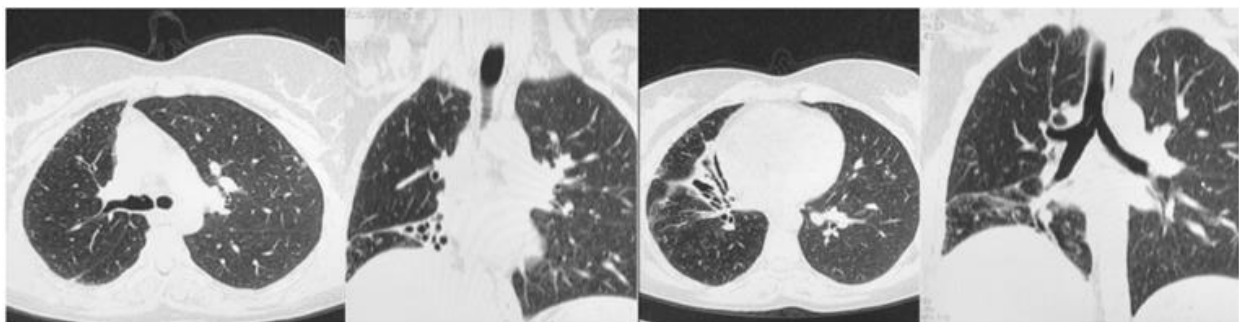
CT scan after 6 month demonstrated complete airway recanalization, persistent bronchiectasis but no direct signs of residual atelectasis ©
